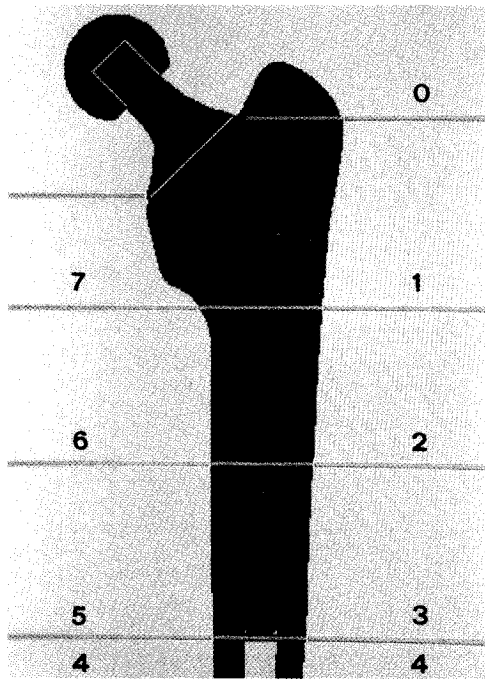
X-rays of seven areas of prosthetic stem.
